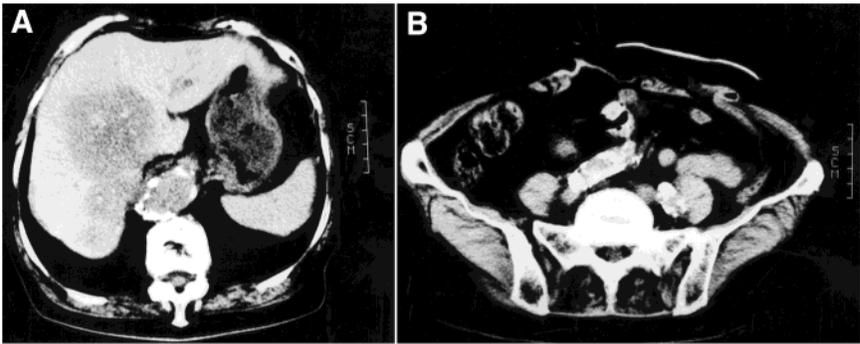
X-ray CT images at the level of (A) the liver and (B) the middle abdomen. A large hepatic metastasis is visible. Typical calcification of the abdominal aorta and iliac arteries is visible also.
